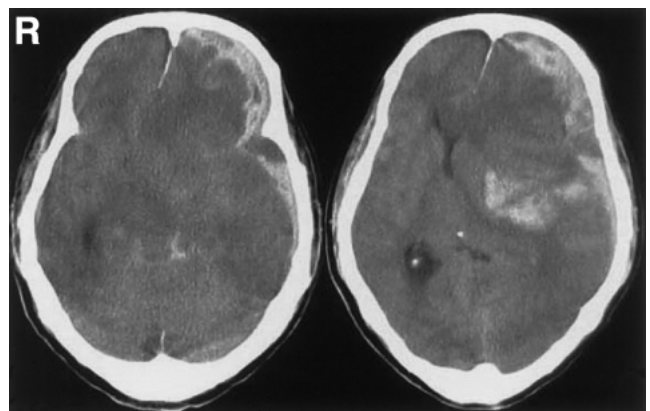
Third computed tomography scans 2.5 hours after thrombolysis disclosing left acute subdural hematoma with marked mass effect and brain shift.
